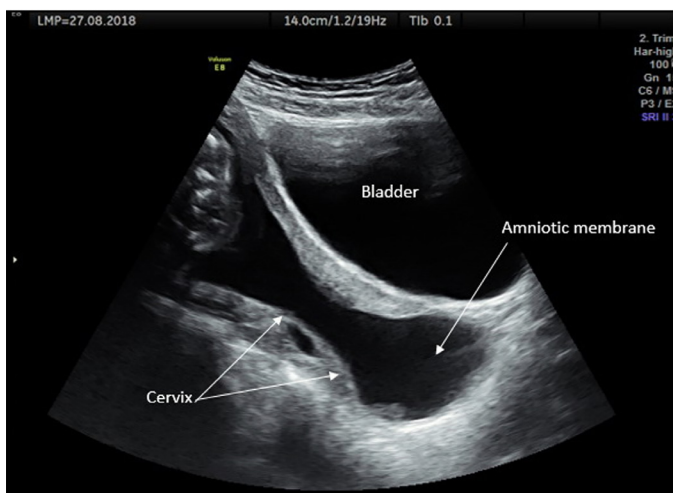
Transabdominal ultrasound image of a patient presented with a fully dilated cervix and amniotic membrane prolapse
